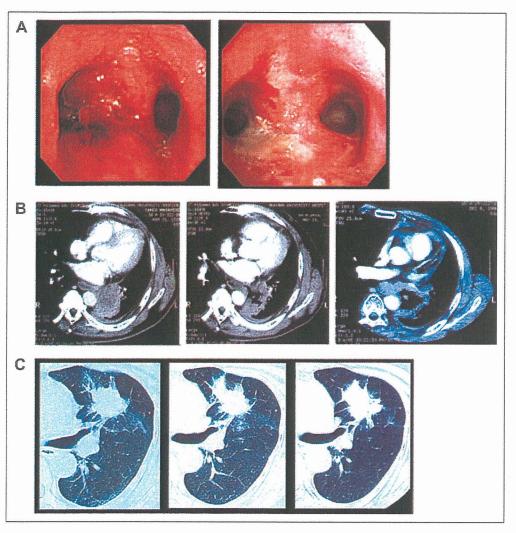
(A) Patient 1 bronchoscopic appearance at the time of enrollment (left) and after four cycles of injections (right). (B) Patient 2 computed tomography scans at baseline (left), at month 2 (middle), and at month 9 (right). (C) Patient 4 computed tomography scans at baseline (left), after four cycles (middle), and 10 cycles (right).
